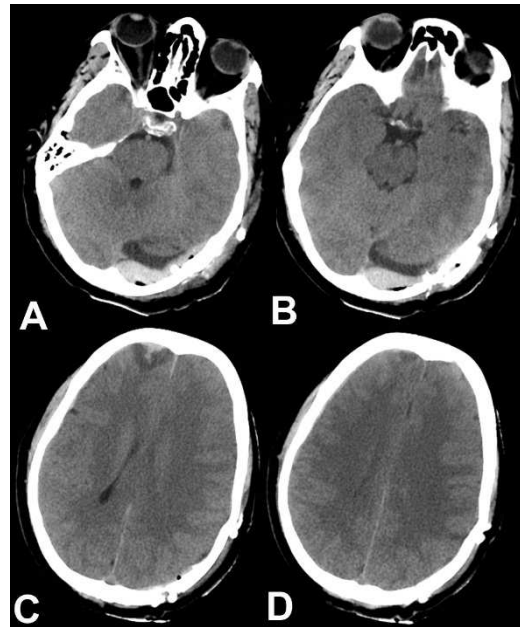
Follow up CT scan performed day 3 after surgery showing good evacuation of extradural hematoma, 4th ventricle is opened, however there is increase in peri-lesional edema around frontal contusion and squashing of the lateral ventricles suggesting increase in cerebral edema
